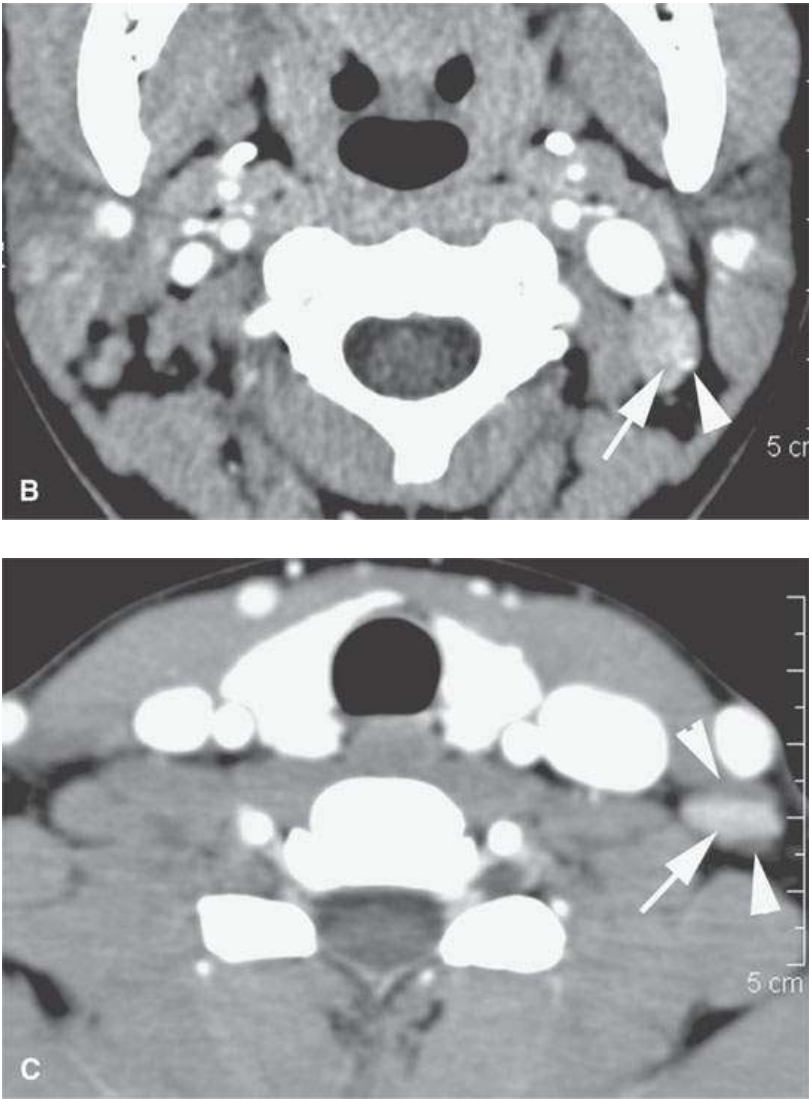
Contrast-enhanced computed tomography of a patient with squamous cell carcinoma of the periauricular region in a typical distribution for such a skin cancer. A: The small node at the parotid tail is suspicious based on small zones of focal enhancement (*arrow*). B: Level 2B node is positive based on the focal areas of abnormal enhancement and/or keratin debris collections and calcification. C: Level 5B node is positive based on focal central enhancing focus *arrow*.
